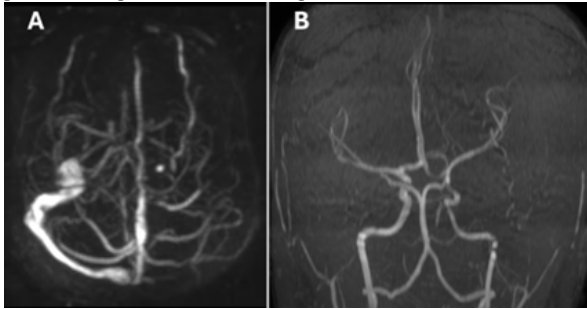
shows the magnetic resonance venogram demonstrating the thrombosis of left transverse sinus, sigmoid sinus and internal jugular vein. Time of flight magnetic resonance imaging reveals patent intracranial arteries. Left middle cerebral artery is elevated due to large temporal lobar infarction.
